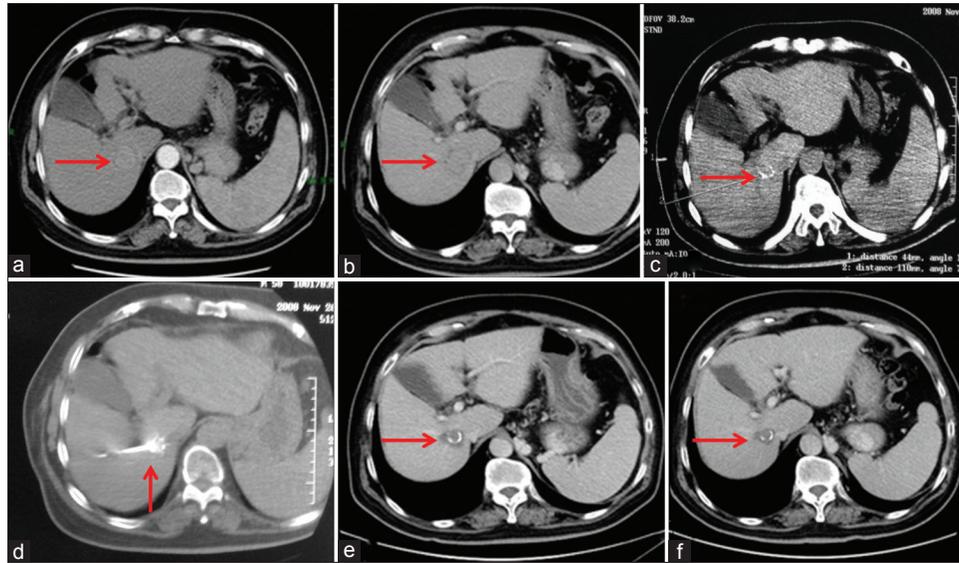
Computed tomography-guided radiofrequency ablation for liver cancer in a 57-year-old man. (a and b) A lesion located in the right lobe, which exhibits fast wash-in in arterial phase and fast wash-out in portal venous phase; (c) The puncture route design; (d) The insertion of the electrode into the tumor, and the multiple subneedle tips unfold and cover the tumor ideally. (e and f) The unenhanced ablation zone, which covers the lesion completely with an enough ablation margin on contrast-enhanced computed tomography 6 months and 1 year later, respectively
